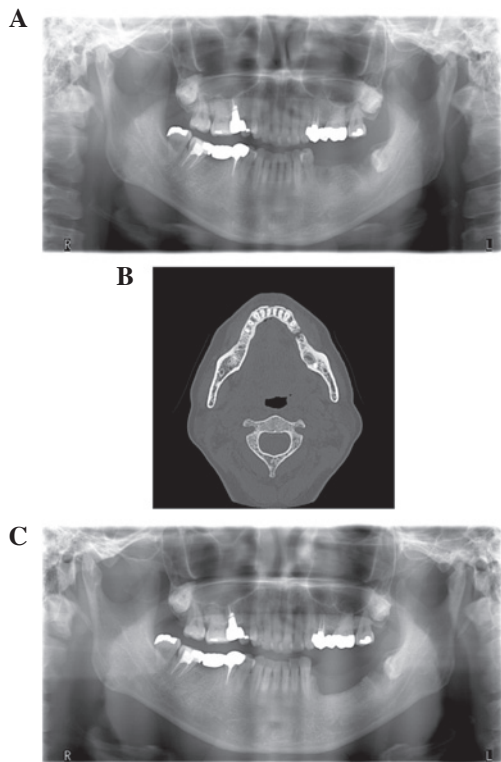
Imaging findings for case 1. (A) Pre-operative panoramic radiographs show bone defects at the site of the mandibular left second premolar. (B) Pre-operative computed tomography shows bone sclerosis and sequestrum formation in the left mandible. (C) Post-operative panoramic radiographs show the resected portion from the left mandible.
